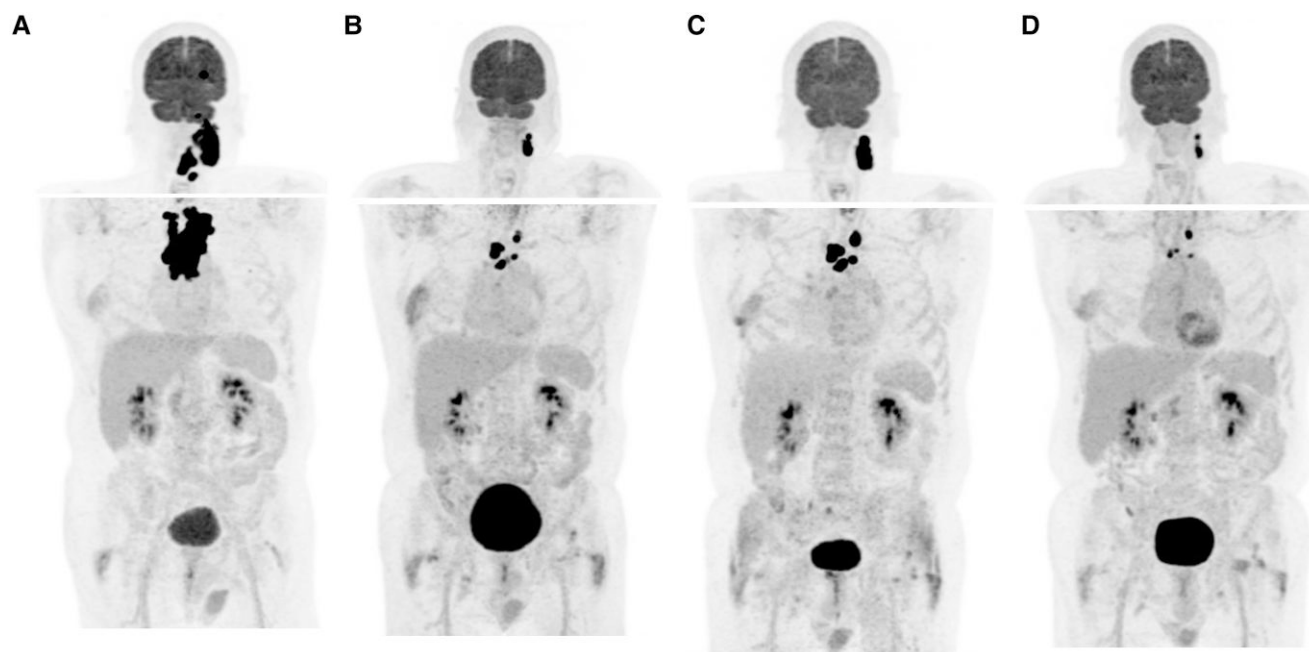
Maximum intensity projection (MIP) ^{18}F -FDG-PET/CT images A, at baseline (July 2021); B, after 10 cycles of pembrolizumab monotherapy demonstrating significant tumor reduction (April 2022); C, after 12 cycles of pembrolizumab showing disease progression in the left neck and upper mediastinum (July 2022); and D, 10 months after radiation therapy completion demonstrating a marked response to pembrolizumab + radiation (June 2023).
